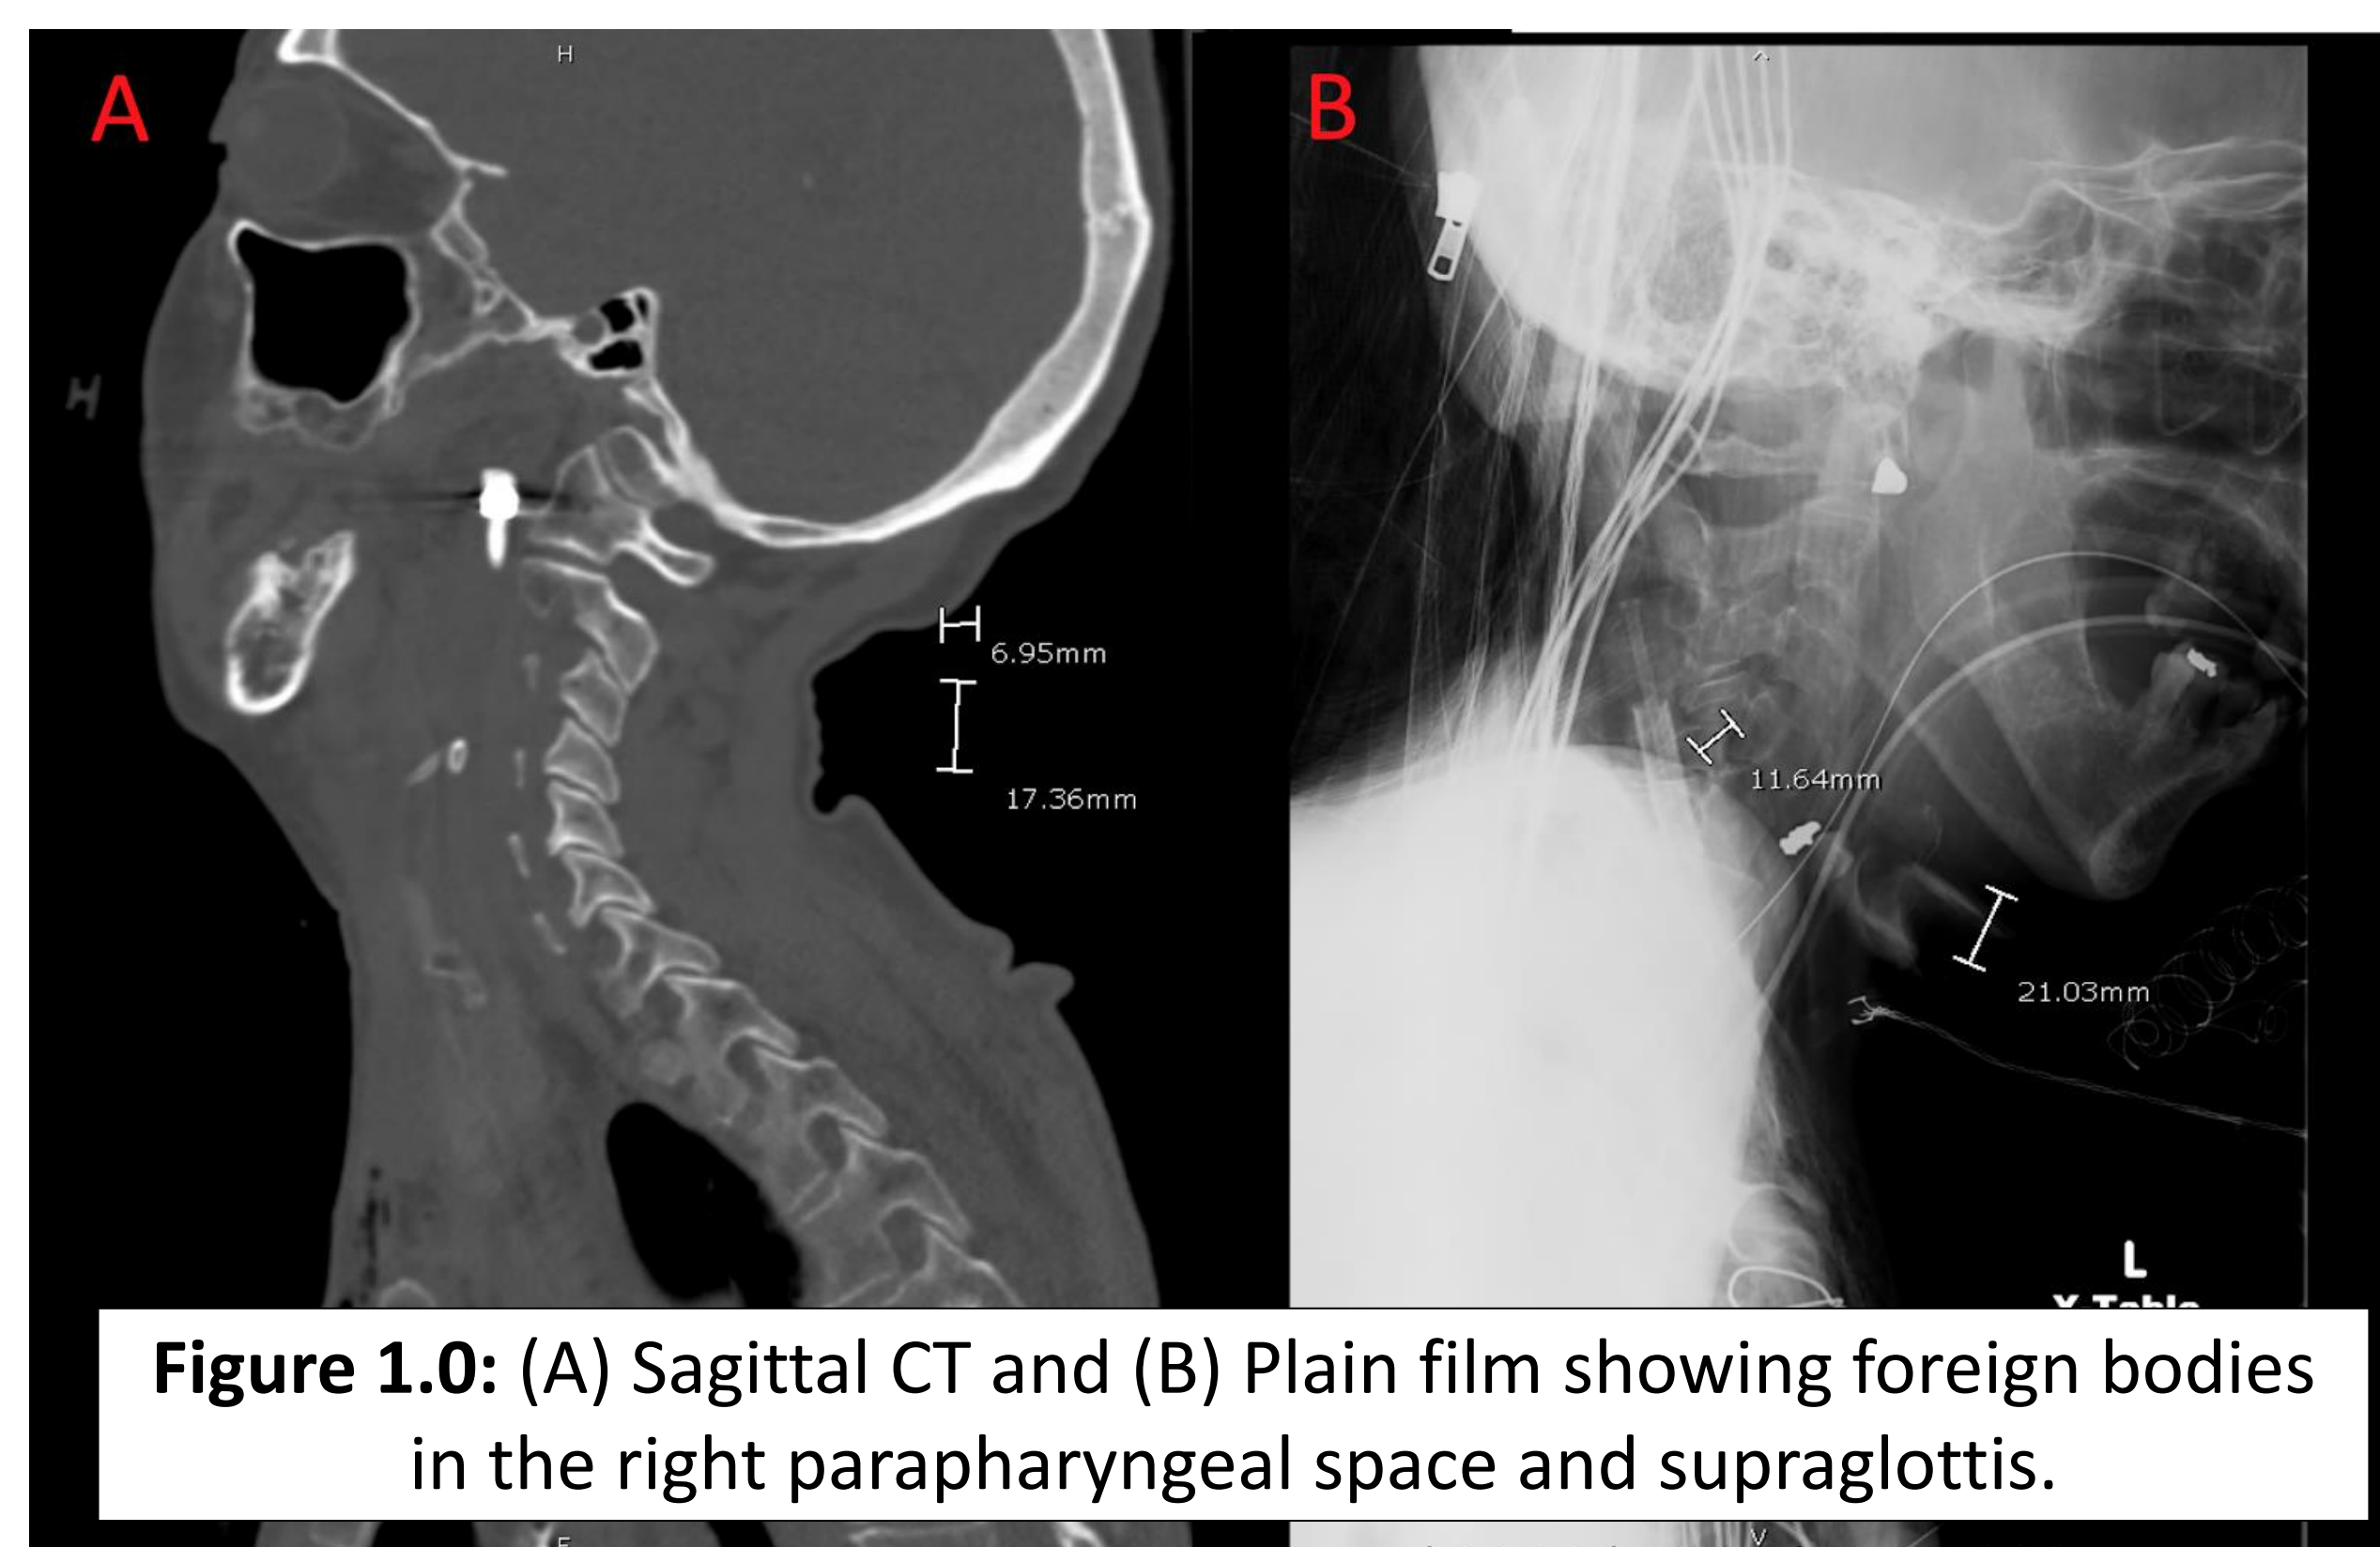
(A) Sagittal CT and (B) Plain film showing foreign bodies in the right parapharyngeal space and supraglottis.
